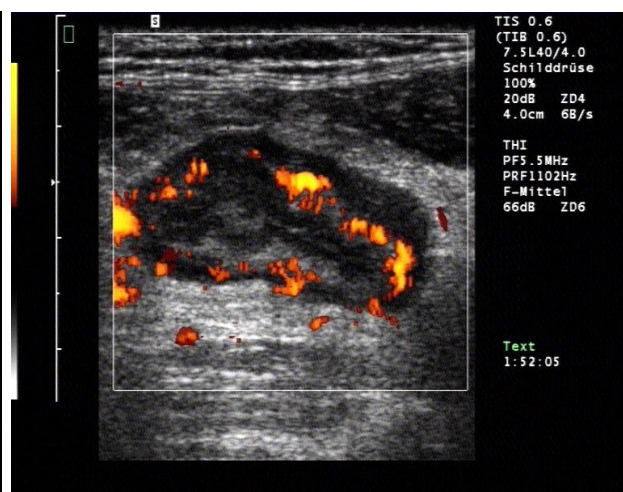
UC activity in Colour Doppler
